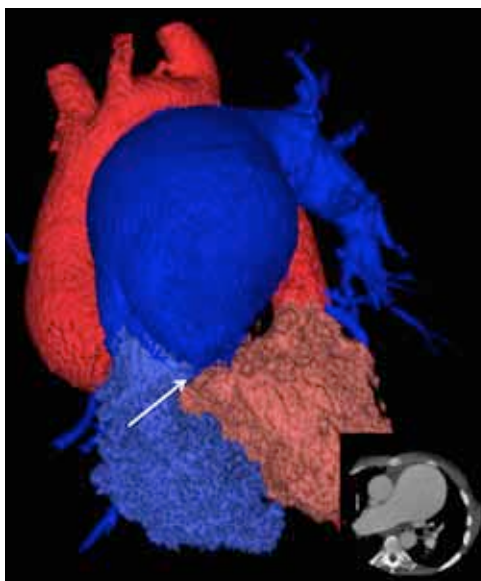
CT 3D reconstruction demonstrating pulmonary artery dilatation and subpulmonic VSD (arrow).
